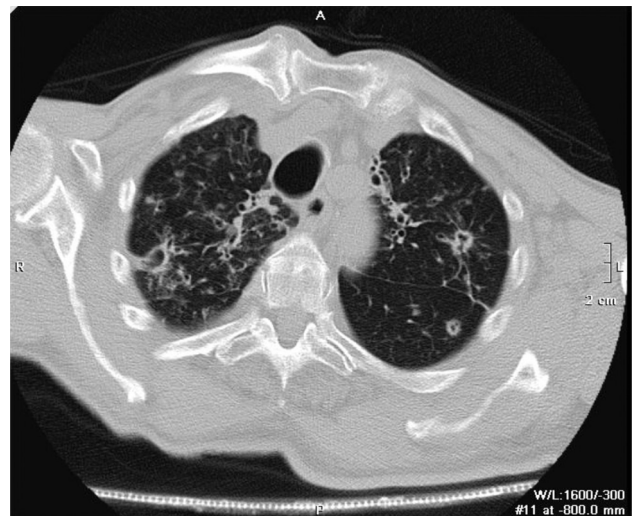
Chest HRCT scan showing multiple nodular lesions with cavitations in upper lung zone bilaterally.
